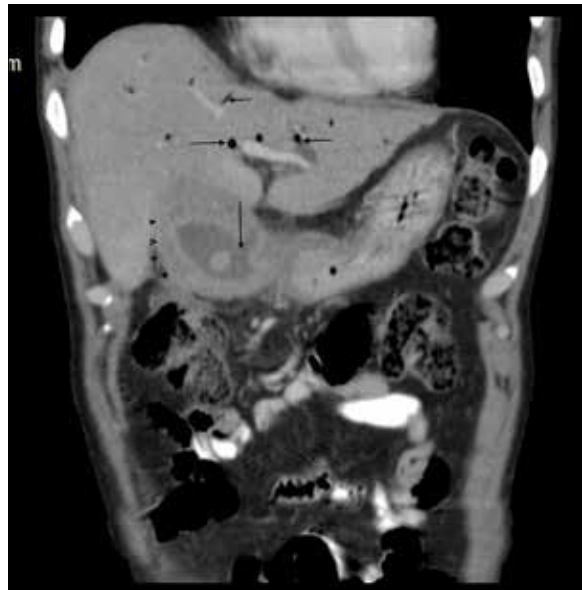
Coronal reformatted contrast-enhanced CT showing multiple air-density foci in IHBRS (horizontal arrows) suggestive of pneumobilia. Breach in the mucosal lining of GB is also seen (vertical arrow). There is concentric thickening of the GB wall showing inhomogeneous enhancement (arrow heads).
